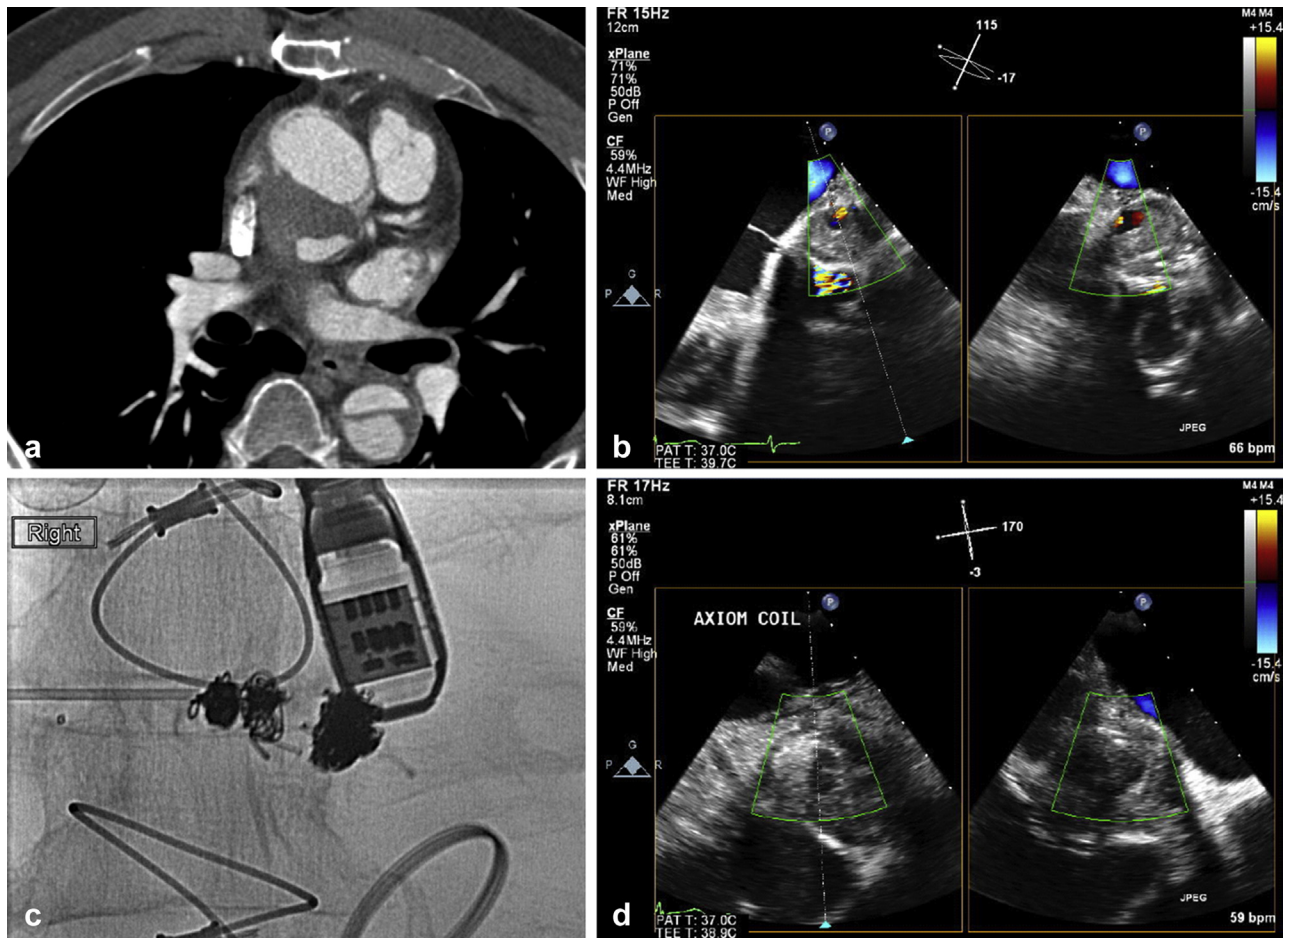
Percutaneous transthoracic approach with TEE assistance in patient 10. (a) Contrast-enhanced CT shows thrombus (arrow) filling most of an AAP arising from the posterior aspect of the true lumen of the aorta (arrowhead). A small amount of contrast filling is seen within the AAP (broad arrow). (b) Preprocedural TEE shows mostly thrombosed AAP (arrow) with a small area of flow seen with Doppler (broad arrow) corresponding to the area of opacification on CT. (c) Spot fluoroscopy image obtained during the intervention shows embolic coils being deployed into the AAP (arrow) through a percutaneous Chiba needle (arrowhead). (d) Postprocedural TEE with Doppler shows no persistent flow within the AAP (arrow).
